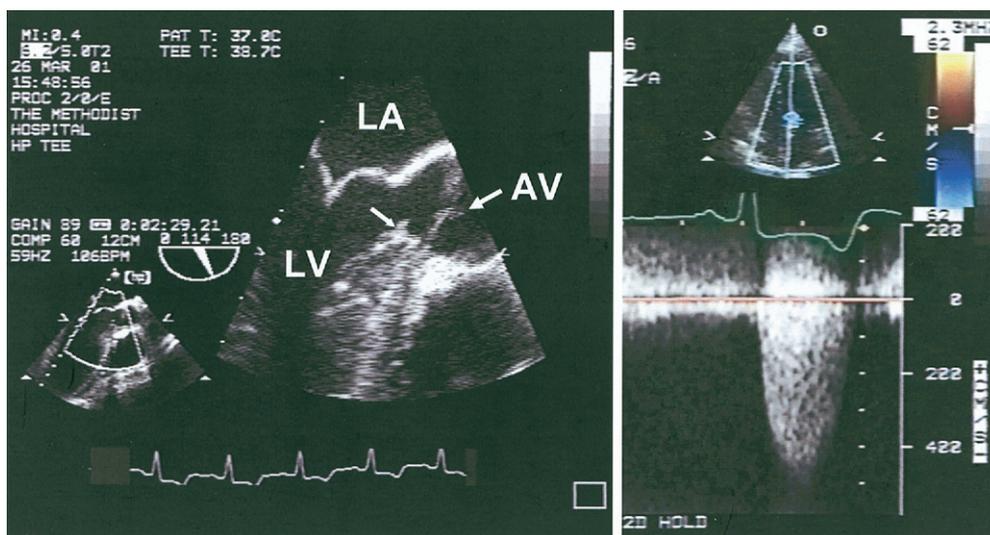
(Left) Transesophageal echocardiography of left ventricular outflow tract showing sub-valvular membrane (arrow). (Right) Continuous wave signal of abnormal flow. Note the early peaking with a gradient of almost 100 mm Hg and the presence of aortic regurgitation. Both are unexpected with dynamic obstruction. AV = aortic valve; LA = left atrium; LV = left ventricle.
